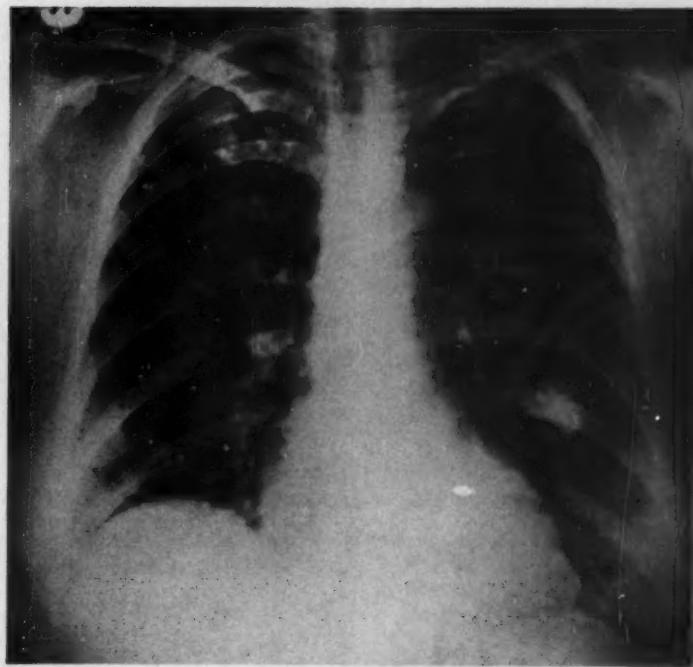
X-ray of August 1958 showing apparent enlargement of the opacities in both lungs.
